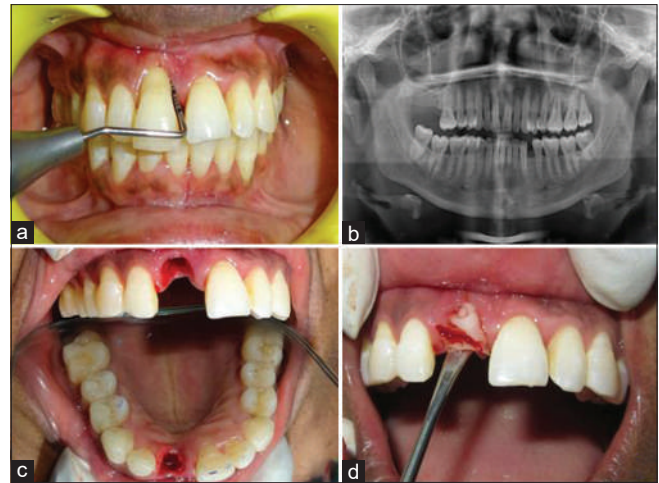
(a) Preoperative clinical view. (b) Preoperative radiographic view. (c) Atraumatic extraction of tooth done and the socket is curetted. (d) Platelet-rich fibrin membrane placed in the extraction socket
